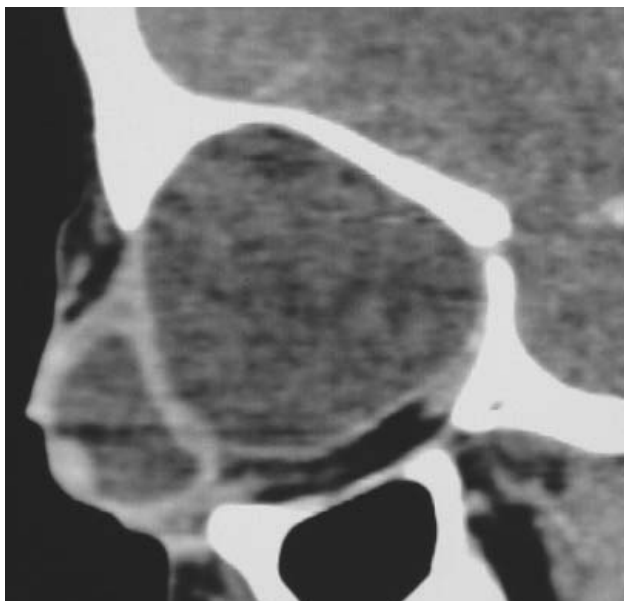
Contrast enhanced CT scan (sagittal image) of the left orbit showing hypodense lesion of near water attenuation causing proptosis of the globe.
